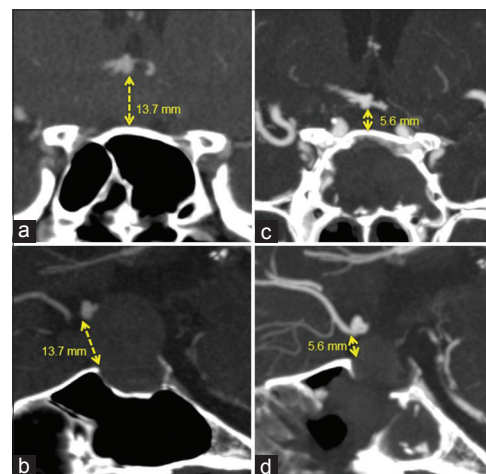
A 65-year-old woman presented with a visual field defect. MR imaging revealed a pituitary macroadenoma that extended to the suprasellar region. A 3-D CTA revealed a small, unruptured AComA aneurysm, with the height of the aneurysm being 13.7 mm from the planum sphenoidale. The AComA aneurysm was detected preoperatively (a: Coronal section; b: Sagittal section). The AComA descent was 8.1 mm during the first week after TSS. A 3-D CTA revealed not only significant descent of the AComA, but also a change in the course of both A1 and A2, thereby suggesting an alteration of the hemodynamic stress in the aneurysm (c: Coronal section; d: Sagittal section)
